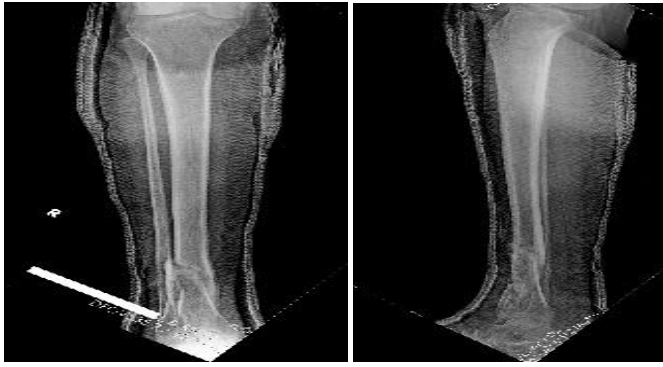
5 month postop x-ray AP view Lat view and showing union
